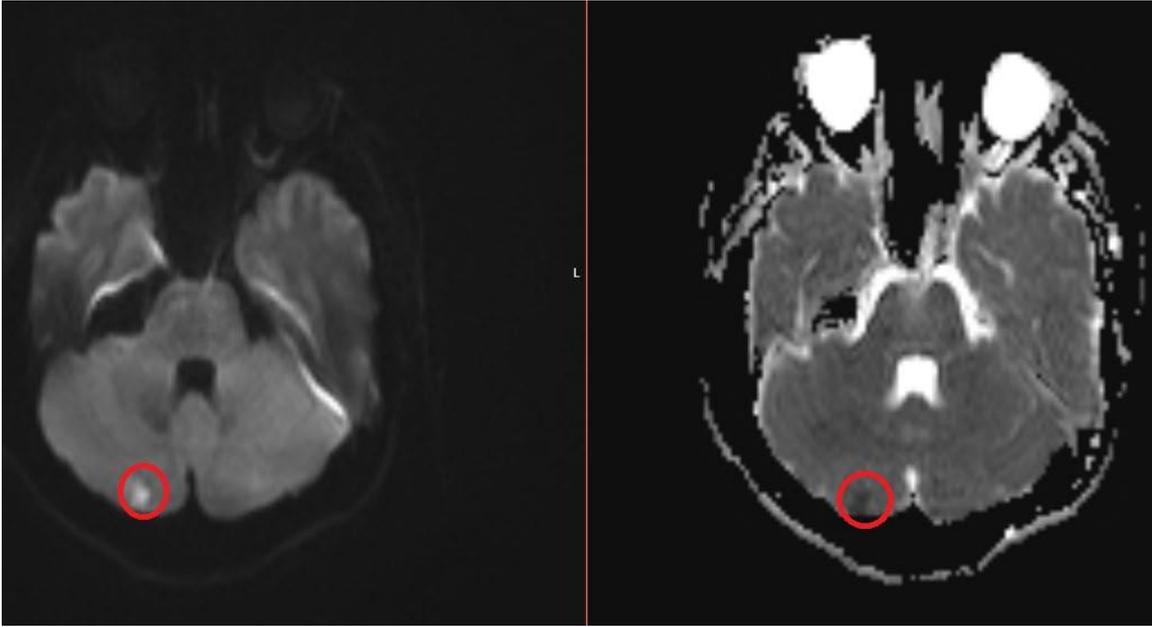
Cerebellar infarct on diffusion MR imaging
